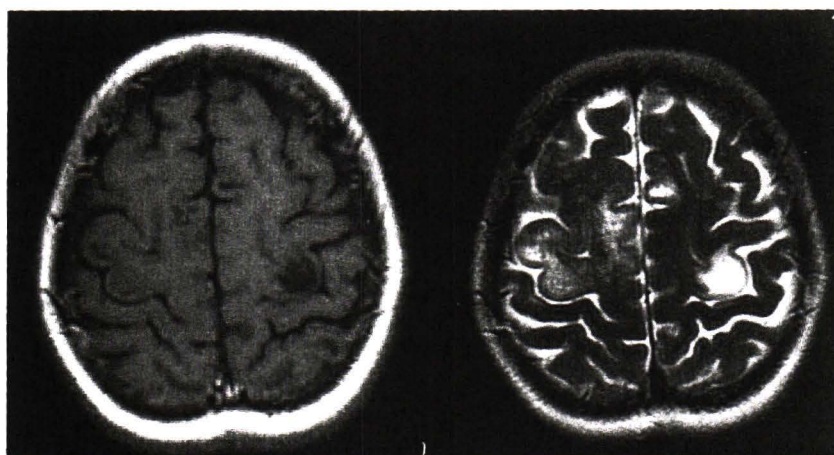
MRI of the brain (T1 and T2).
